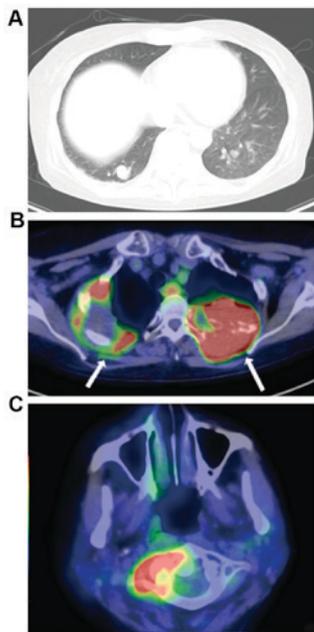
Radiological findings for case 2. (A) The image of CT for pulmonary nodule. (B) The fusion image of 18-FDG-PET/CT in horizontal plane. The left pulmonary nodule exhibited a notably high 18-FDG uptake ( $SUV_{max} > 20.1$ ). The right pleural thickening also demonstrated marked 18-FDG uptake ( $SUV_{max} > 10.1$ ). (C) A lesion exhibiting high 18-FDG uptake ( $SUV_{max} > 12.1$ ) was detected in the right side of the atlas vertebra. (D) The fusion image of 18-FDG-PET/CT in the coronal plane. Numerous lesions had a positive accumulation of 18-FDG (arrows). CT, computed tomography; 18-FDG-PET/CT, 2-deoxy-2-(fluorine-18)-fluoro-D-glucose positron emission tomography/CT;  $SUV_{max}$ , maximum standard uptake value.
